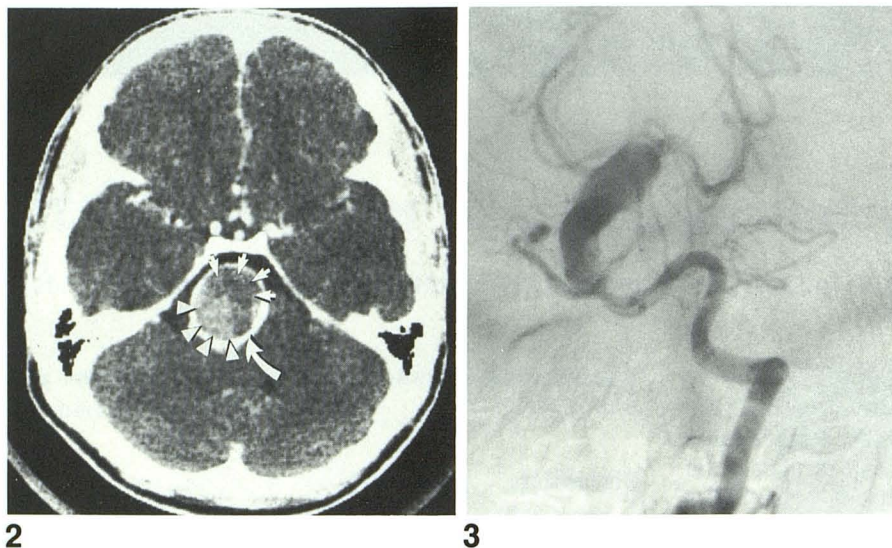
Postinfusion CT scan shows lumen (arrowheads), clot (short arrows), and rim of calcification (curved arrow).
